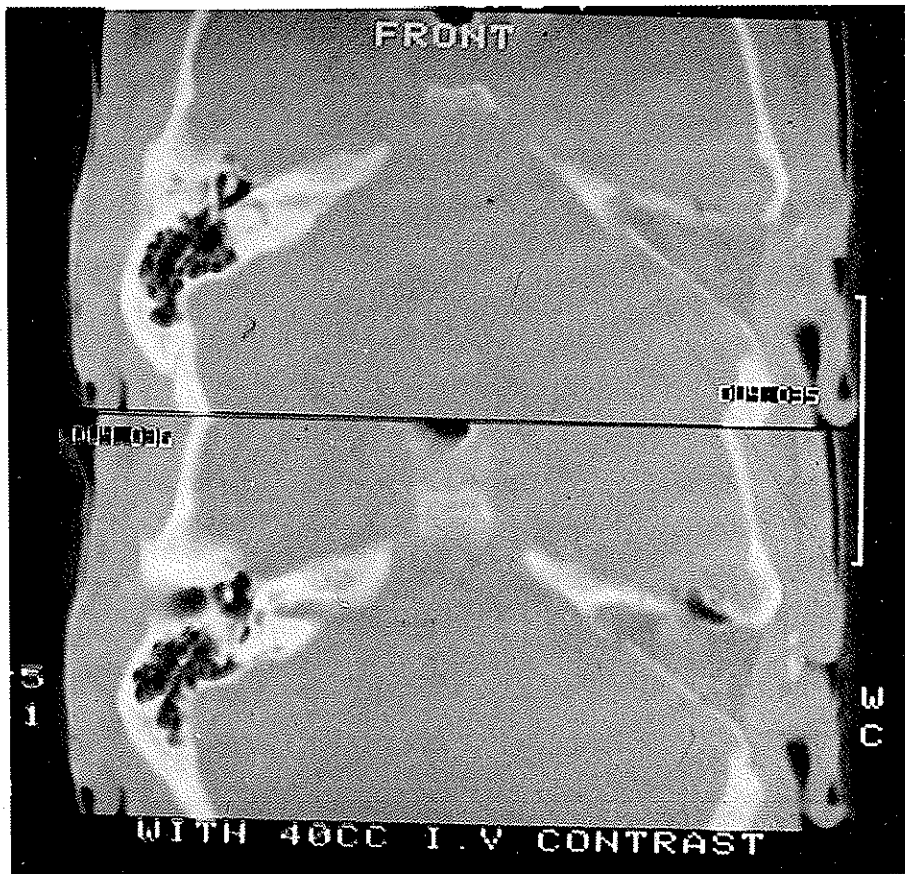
Post-op CT Scan of the petrous bone shows petrous bone removal with tumor eradication with translabyrinthine approach.
